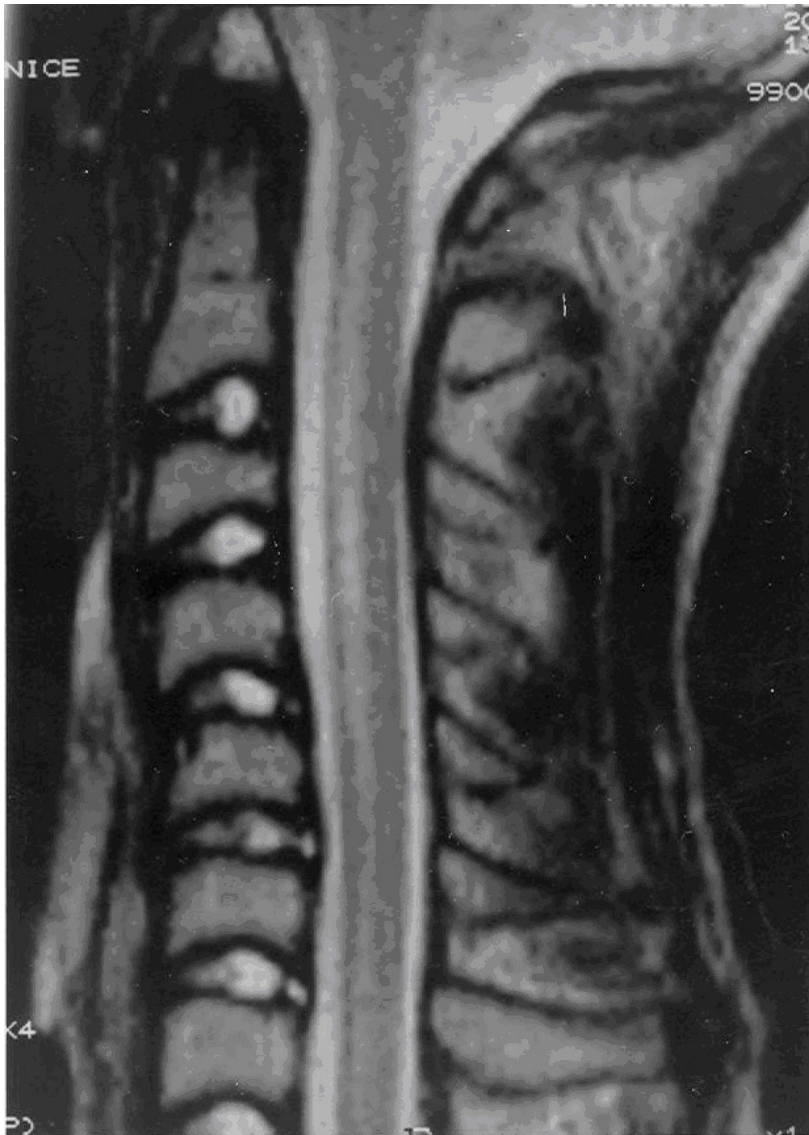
Patient with lupus and development of spastic paraparesis. MRI showed LETM of the spinal cord. NMO antibodies were negative.
